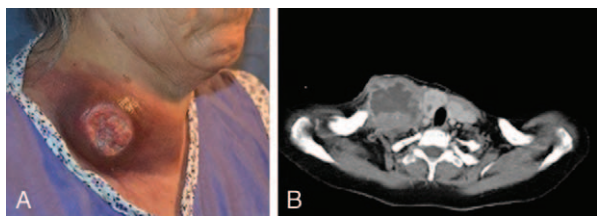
A, The appearance of the mass 3 weeks after incisional biopsy. B, Axial computed tomography with contrast showing a mass at right neck region with central necrosis and contrast uptake.
